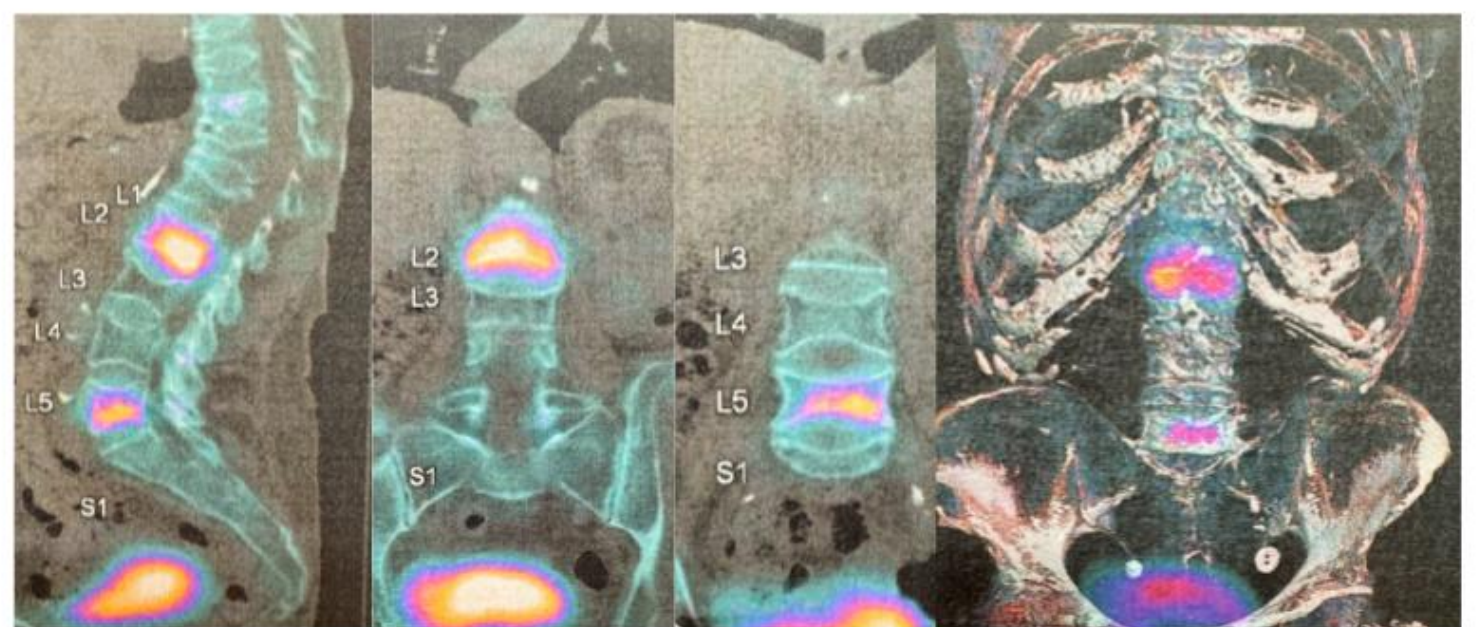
Sagittal, coronal, and 3D fused SPECT-TC demonstrates increased activity at the L2 and L5 vertebral bodies, compatible with unconsolidated vertebral compression fractures.
